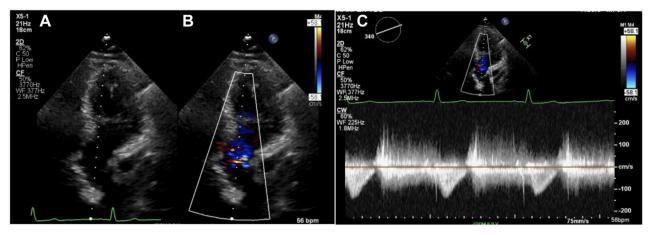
Two-dimensional TTE without (A) and with (B) color-flow Doppler-guided continuous-wave Doppler spectrum (C) demonstrates suboptimal signal quality precluding measurement of the pressure half-time.
